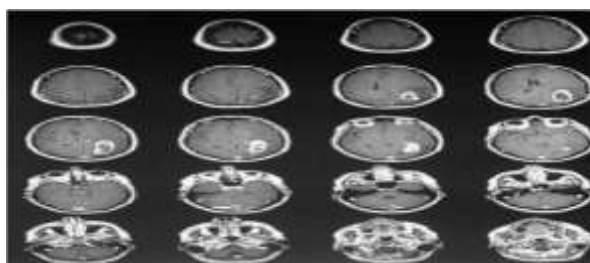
MRI Images of Brain
